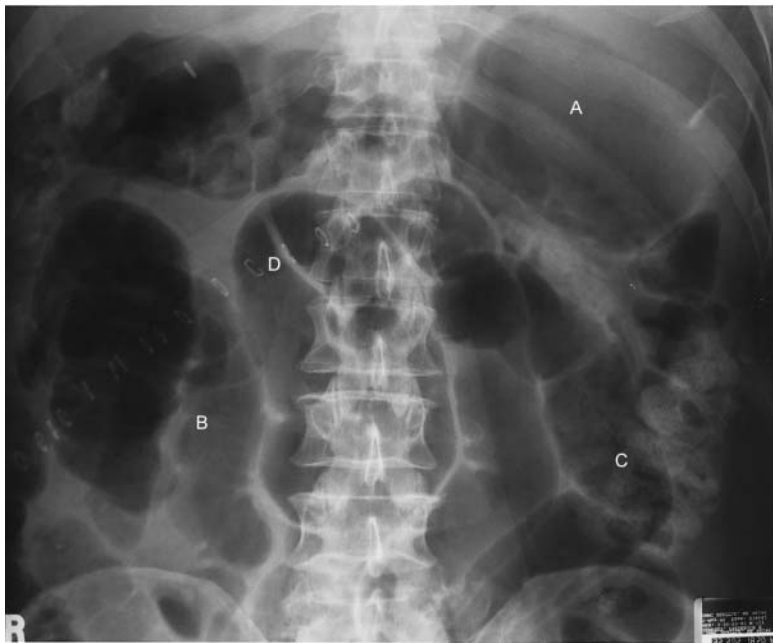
Radiograph from a patient with postoperative ileus shows massive gastric distention (A), distended small bowel loops (B), air throughout the colon, mild dilatation of the sigmoid colon (C) with air mixed with stool, and a haustral fold in the apex of the sigmoid colon (D).
